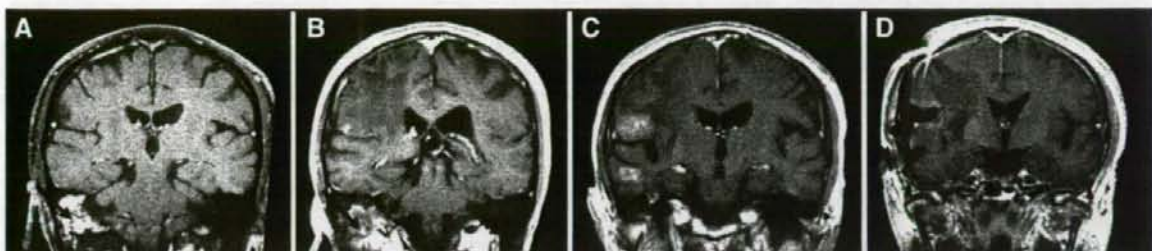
Serial Gd-enhanced T1-weighted coronal MRI scans of Patient 2. A, MRI scan obtained just before BNCT. The black arrow shows the Gd-enhanced, growing tumor. B, MRI scan obtained 2 years after BNCT. The black arrow shows a decrease in the intensity of the Gd-enhanced area. Note
